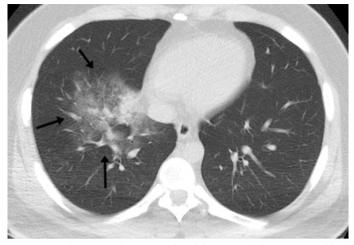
Axial CT image shows central-unilobar ground-glass opacities (black arrow). Indeterminate appearance for SARS-COV-2.
